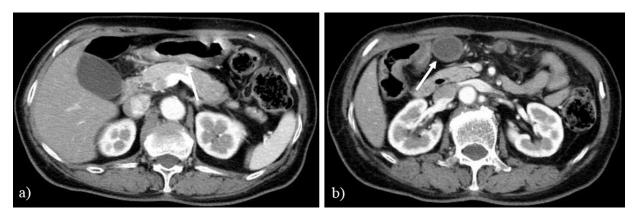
(Case 3) Abdominal contrast-enhanced computed tomography after neoadjuvant chemotherapy. *a*, Wall hypertrophy of the posterior wall of the antrum was reduced (*arrow*). *b*, The swelling of the No.6 lymph node was reduced (*arrow*).
